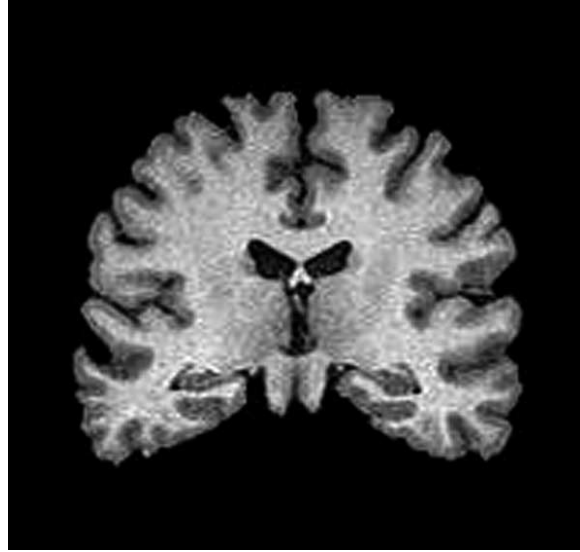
Coronal slice of T1-weighted cerebral MRI
